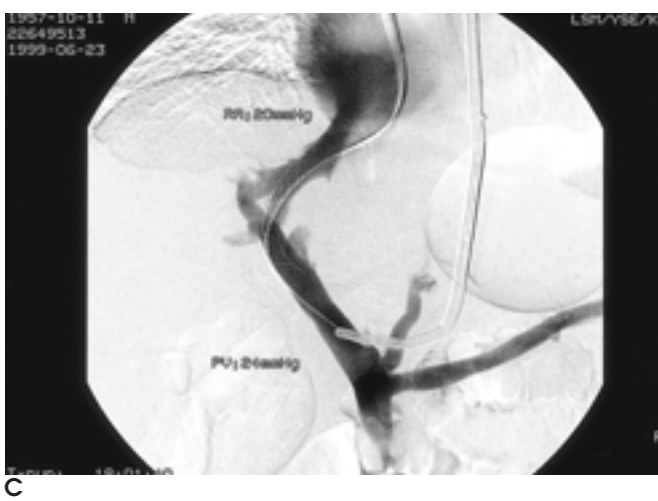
Pitfall in sonography after TIPS suggesting stenosis.
